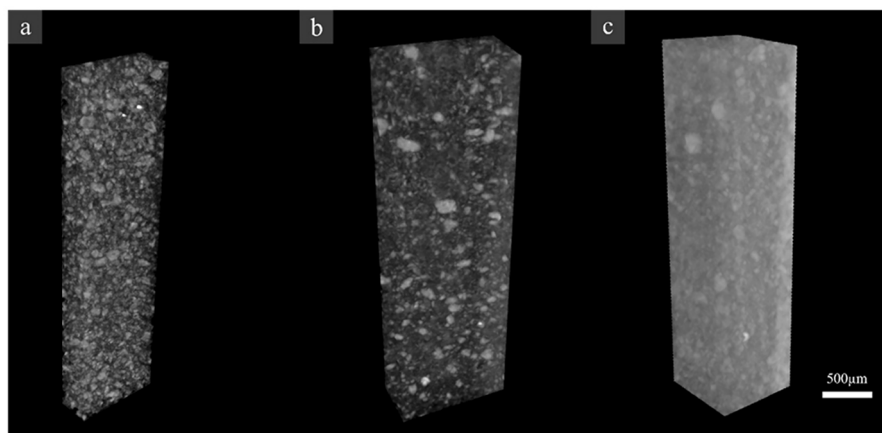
Maximum intensity projection μ CT reconstructions of OP5 (a), OPP5 (b) and OPP8 (c).
